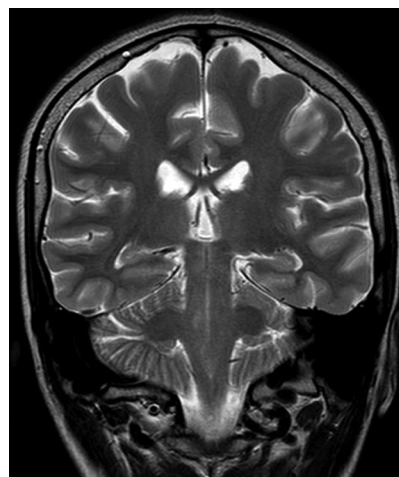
Brain magnetic resonance imaging shows a diffuse leptomeningeal inflammatory involvement
